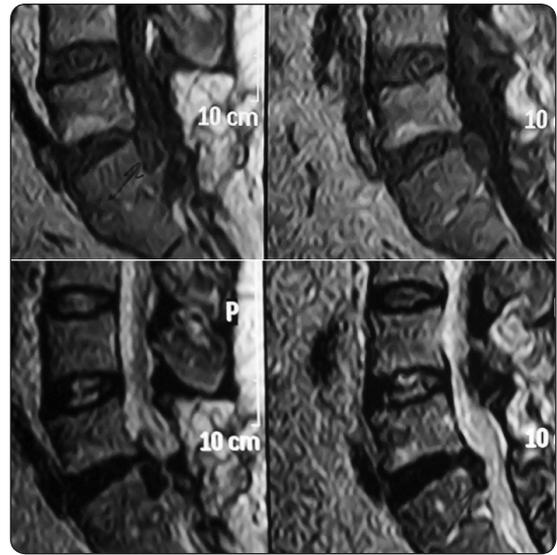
Sagittal MR images (T1-weighted image (upper row) and T2-weighted image (lower row)) for a patient with L4-5 disc herniation associated with type II MC. The patient underwent simple discectomy without fusion with removal of the caudally migrated disc fragment.
